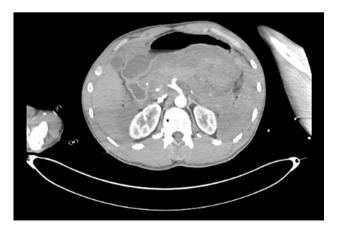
CT Scan imaging of gunshot wound injuries to the pancreatic neck and tail
